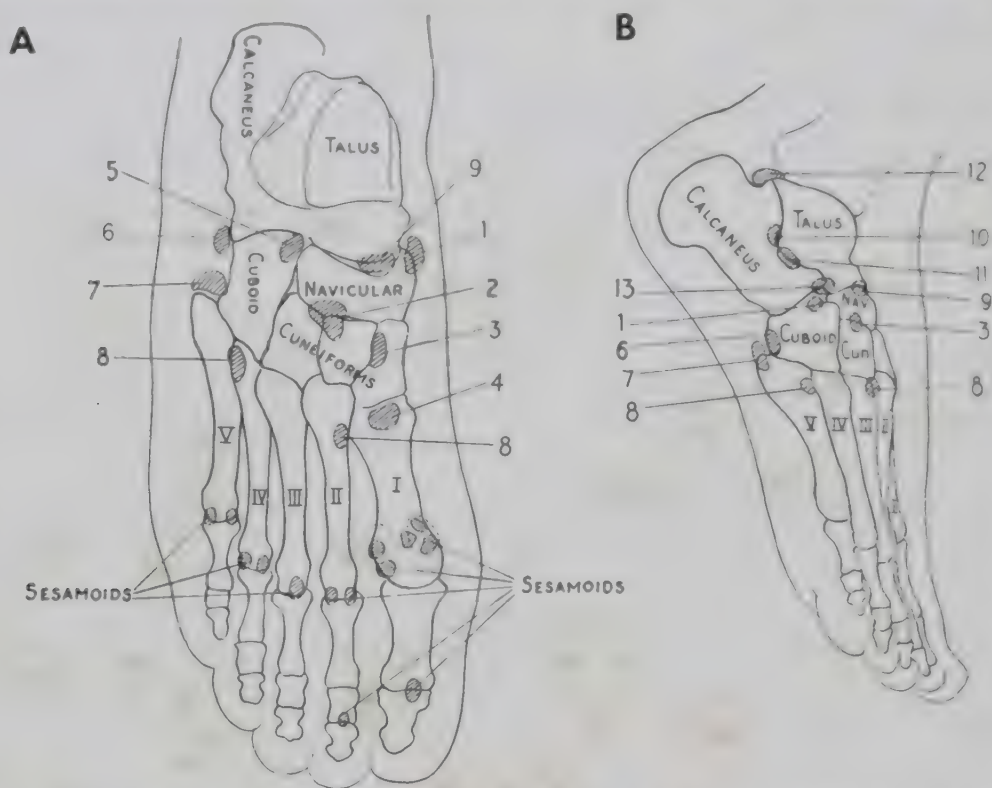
Normal supernumerary ossicles of the feet. *A*, Ventrodorsal, and *B*, lateral projection. 1, Os tibiae externum; 2, processus uncinatus; 3, os intercuneiforme; 4, pars peronea metatarsalia I; 5, cuboides secundarium; 6, os peroneum; 7, os vesalianum; 8, os intermetatarsium; 9, accessory navicular; 10, talus accessories; 11, os sustentaculum; 12, os trigonum; 13, calcaneus secundarium. (Caffey, J.: *Pediatric X-Ray Diagnosis*, Year Book Publishers, Inc.)
